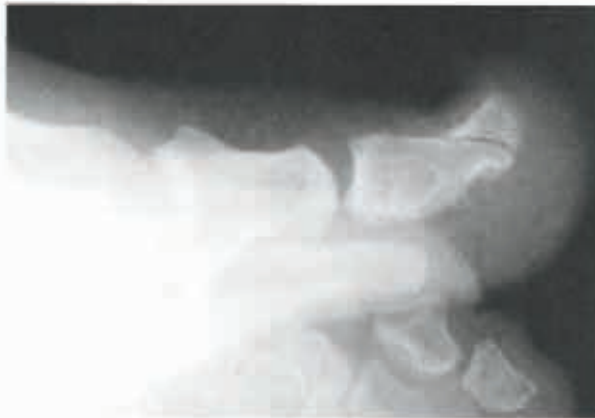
Lateral radiographic view of the foot showing subungual exostosis.<sup>2</sup>
